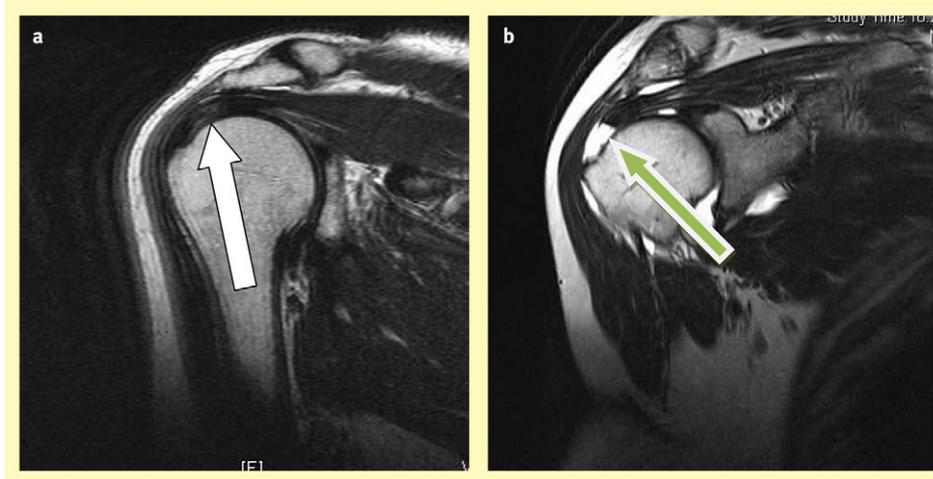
Two images from shoulder MRI. Image a, on the left demonstrates increased signal (white arrow) within the supraspinatus tendon. This represents the tendinopathy within the substance of the tendon. Image b on the right clearly shows a full thickness tear of the supraspinatus tendon (green arrow).
